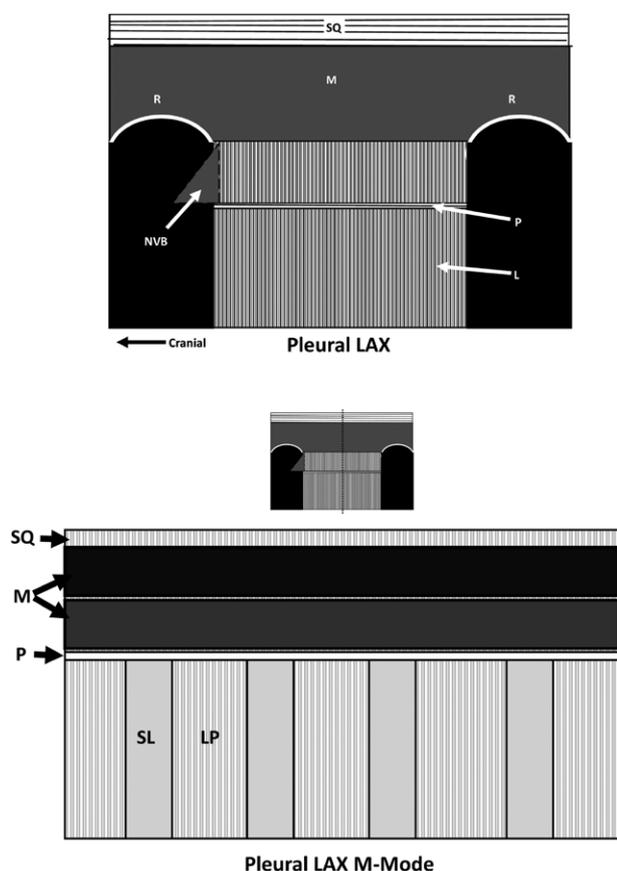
Pleural ultrasound views. Pleural LAX = pleural long axis; Pleural LAX M-Mode = pleural long axis M-mode; SQ = subcutaneous tissue; R = rib; M = muscle; NVB = neurovascular bundle; P = pleura; L = lung; SL = sliding lung; LP = lung parenchyma.
